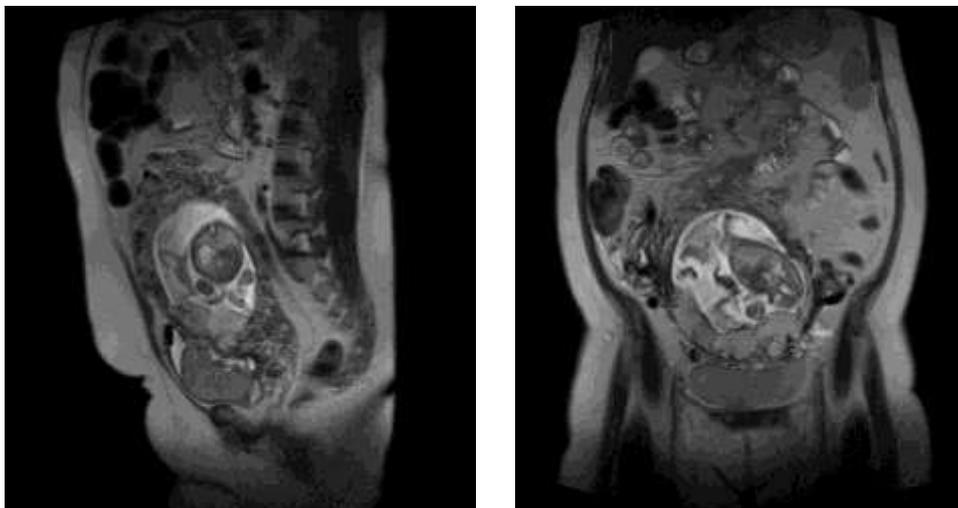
Sagittal and coronal T2 HASTE and T2 trufi magnetic resonance images showing marginal placenta previa with a heterogeneous placenta due to dark intraplacental bands and heterogeneous abnormal vascularity invading into the dome and posterior wall of the bladder
